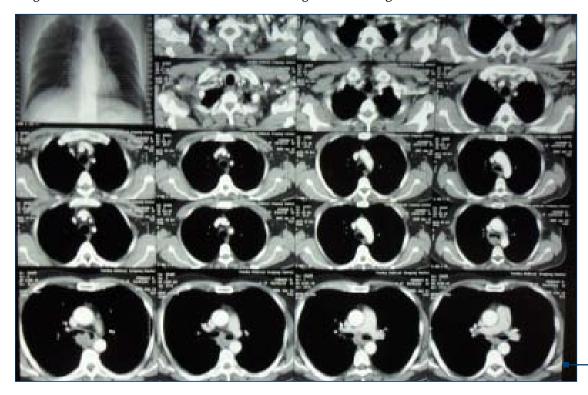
Chest CT after initial sessions of interventions
